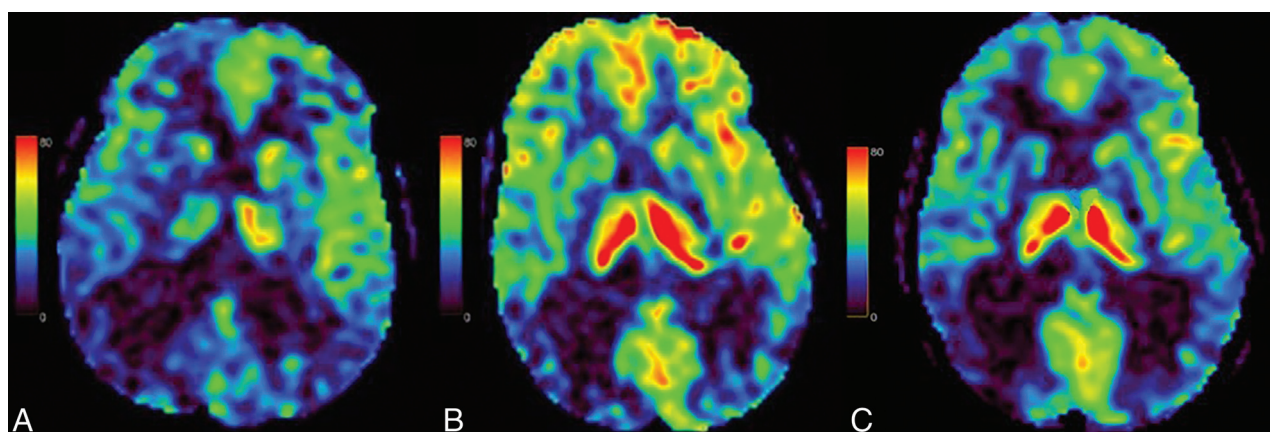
Patient 2 CBF maps. A, Baseline CBF map showing hypoperfusion in the bilateral frontal, parietal, and occipital lobes, more pronounced on the right. B, CBF map before the fifth dose of lecanemab, demonstrating marked improvement in cerebral perfusion, especially in the bilateral frontal lobes. C, CBF map before the seventh dose of lecanemab, showing decreased overall perfusion compared with the prior MRI and no substantial change from baseline.
